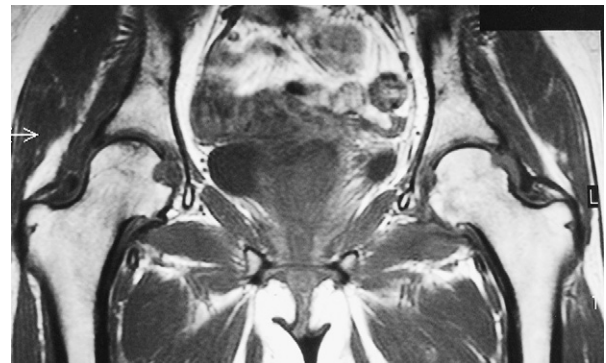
MRI left hip 6 weeks after closed reduction.
